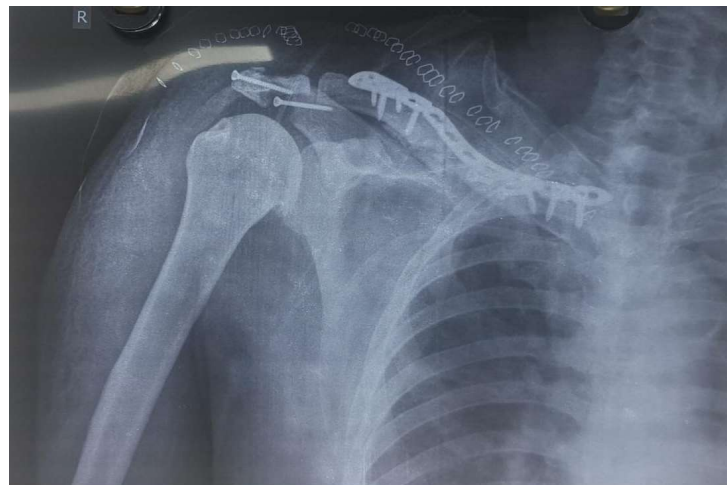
Post op xray after 1st surgery
